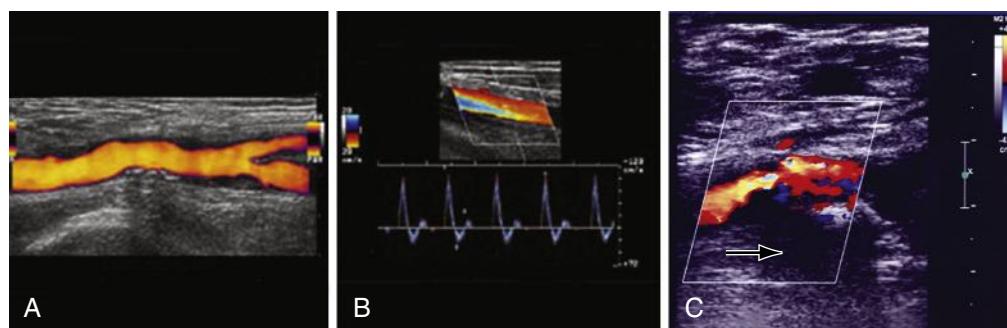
Duplex Mapping of the Common Femoral Artery. (A) Longitudinal view of the common femoral artery (power imaging) and the bifurcation of the superficial and deep femoral arteries. (B) Doppler spectral waveform from a normal right femoral artery. The Doppler signal was obtained from a longitudinal view with the Doppler sample volume placed in the middle of the lumen. The characteristic triphasic Doppler signal shows a brisk upstroke to peak systole, reversal of blood flow during early diastole, and a forward flow component during late diastole. (C) Longitudinal view of the common femoral artery with greater than 50% stenosis due to posterior plaque.
